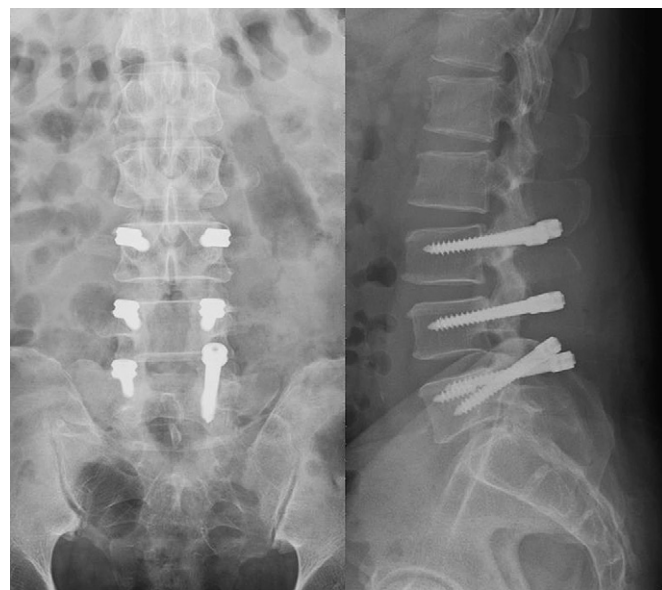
The patient underwent revision surgery with Dynesys. Radiography 12 months after surgery showed reimplantation of the left L5 pedicle screw and augmentation of both L5 pedicle screw holes using autologous bone graft.
